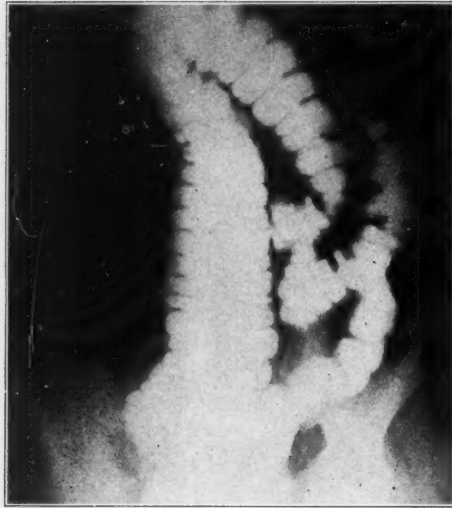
Roentgenogram showing an abnormal position of the proximal colon. Scarcely any of the colon is seen to the right of the midline. The cecum and appendix are low in the pelvis.
